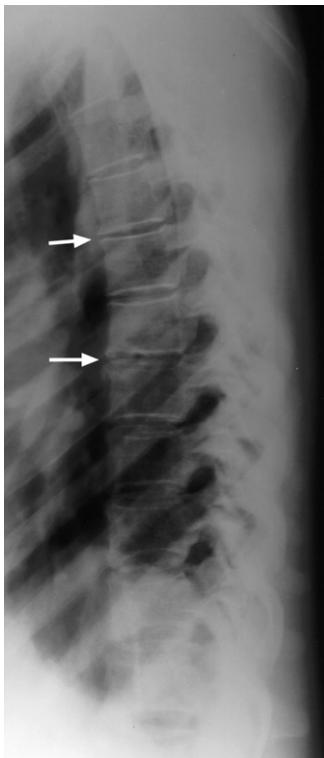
Thoracic spine lateral plain X-ray image. This shows some early osteophytes anteriorly adjacent to the discs at approximately the T4–7 levels.
